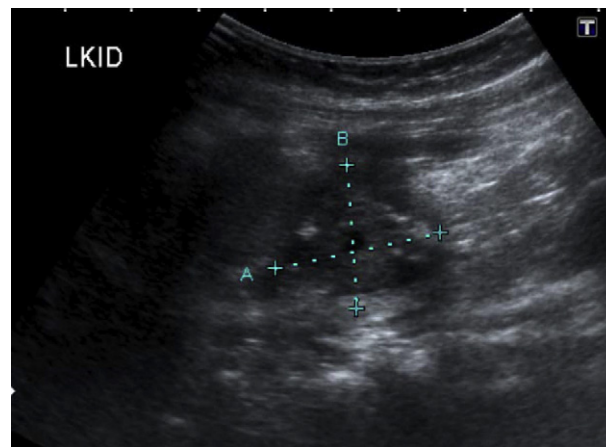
Ultrasound of the kidney at age 3 months. The kidney has shrunk to 2.5 cm in length and there was lack of renal structure.
